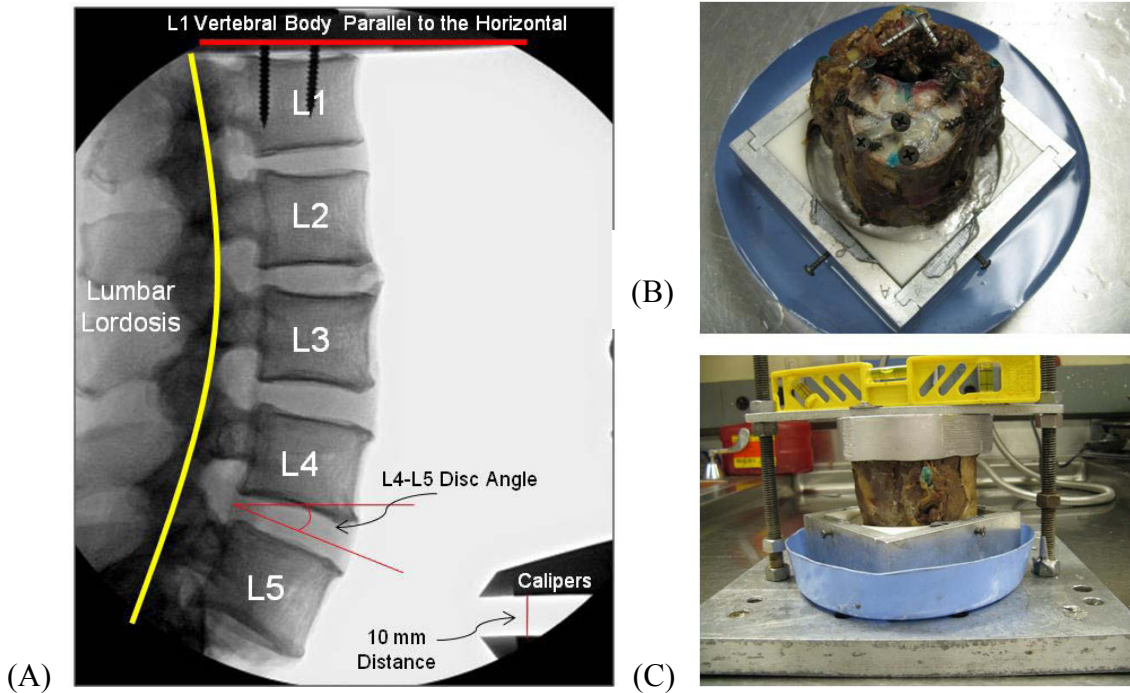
Disarticulation and Potting of the L4-L5 MSU in Its Natural Alignment. (A) A calibrated lateral radiographic of the full lumbar spine in its neutral upright alignment was used to determine the L4-L5 disc angle, which was maintained during potting. (B) Wood screws were placed into the endplates and spinous process to provide additional fixation of the vertebral body to the potting material. (C) The L4-L5 MSU was mounted in its natural alignment and centered within the pot. Care was taken to ensure that the pots were parallel to each other and the horizontal datum.
